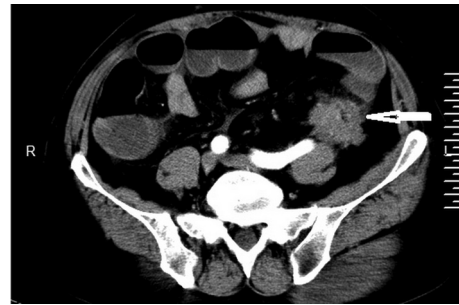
Computed tomography scan showing descending colon mass (marked by arrow).
